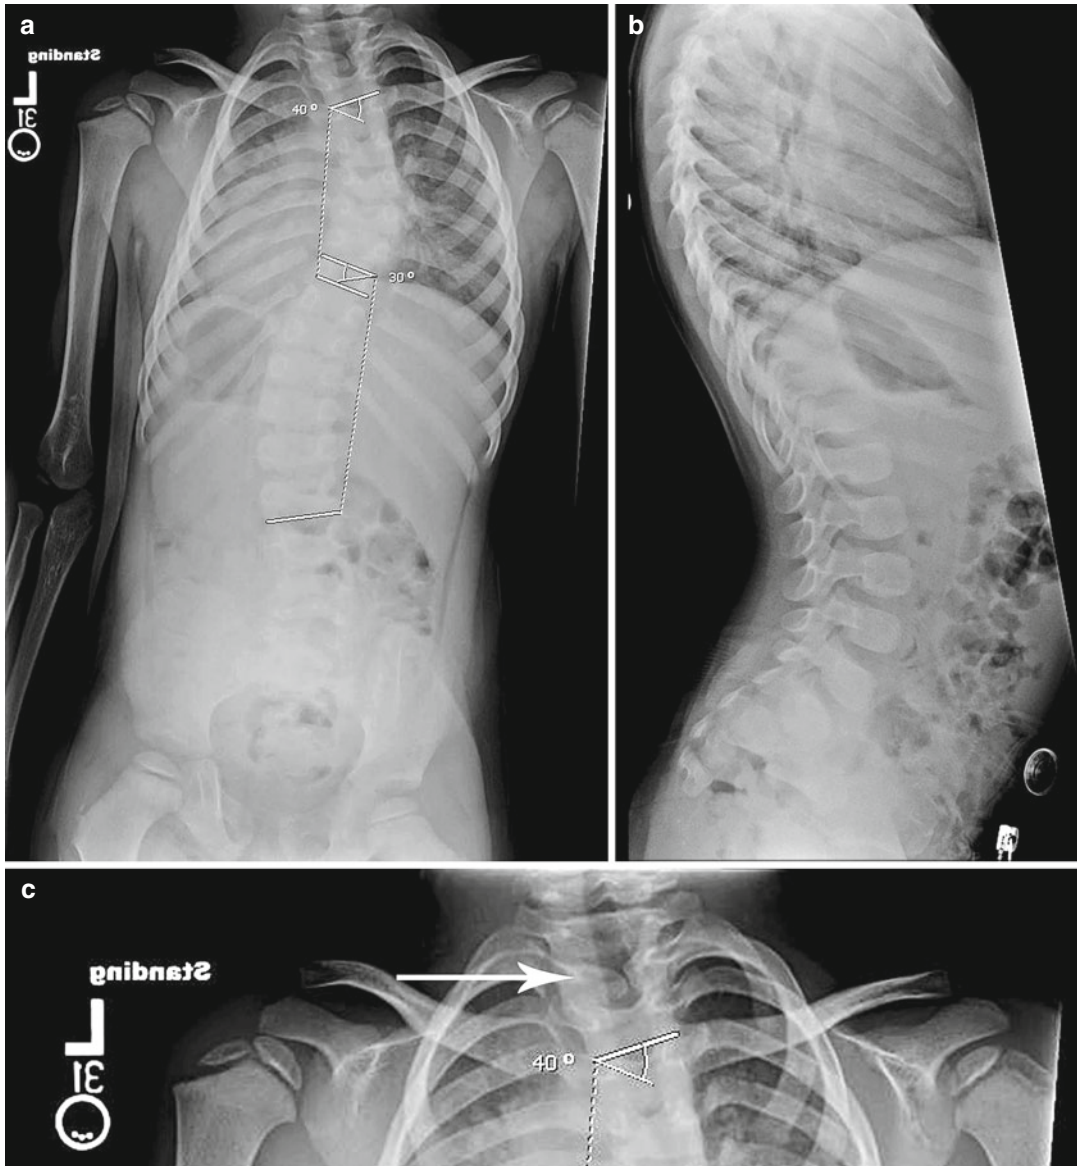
X-rays of the case example. (a) Posteroanterior and (b) lateral radiographs showing the thoracic and thoracolumbar scoliotic curves with thoracic cage asymmetry.
